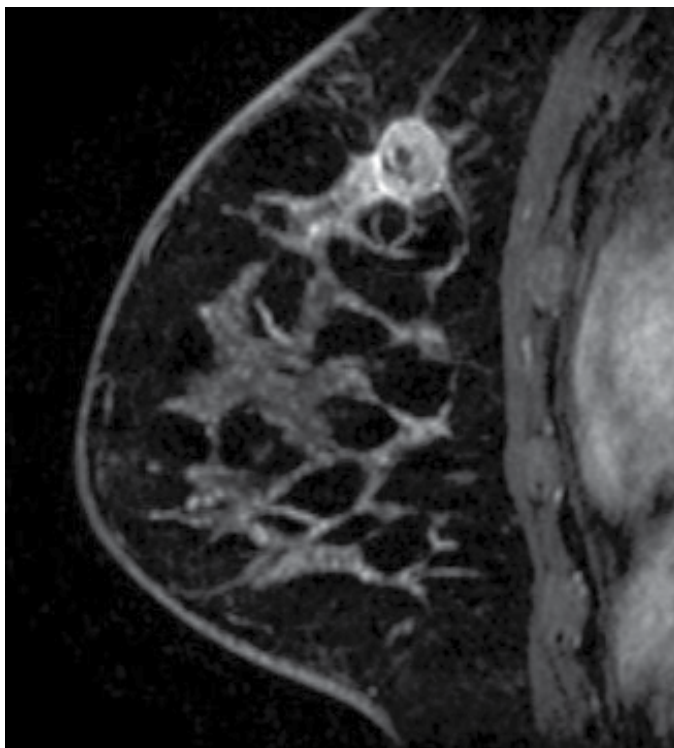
A second representative case of IDC, MRI.
